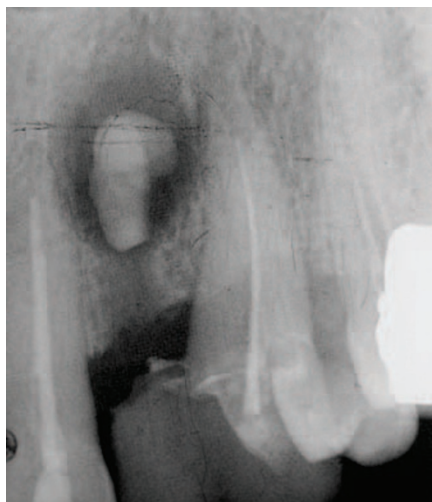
Pre-operative radiograph showing radio-opaque material in the 22 site
